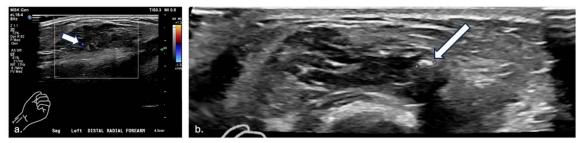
18-year-old female with splenic lymphangioma. Ultrasound images of the distal lateral left forearm demonstrate a complex 4.7 x 1.9 x 2.6 cm lesion within the distal lateral soft tissue of the left forearm. Doppler imaging of the lesion (A) demonstrates slow/venous blood flow within the lesion (arrow), and on grayscale imaging (B) the lesion contains focal calcification (arrow).
